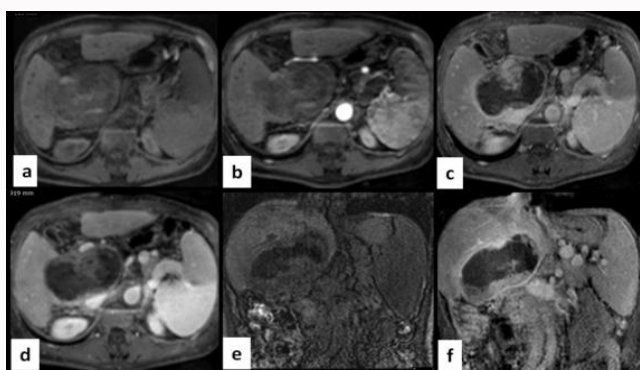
Dynamic MRI abdomen findings: A well-defined lesion is seen in caudate lobe appearing: hypointense on pre-contrast T1 (a), and showing progressive peripheral enhancement with eccentric enhancing soft tissue component on arterial (b), portal venous (c) and delayed phases (d). Same is shown in coronal pre-contrast T1 (e) and post-contrast delayed phase T1 (f) images.
